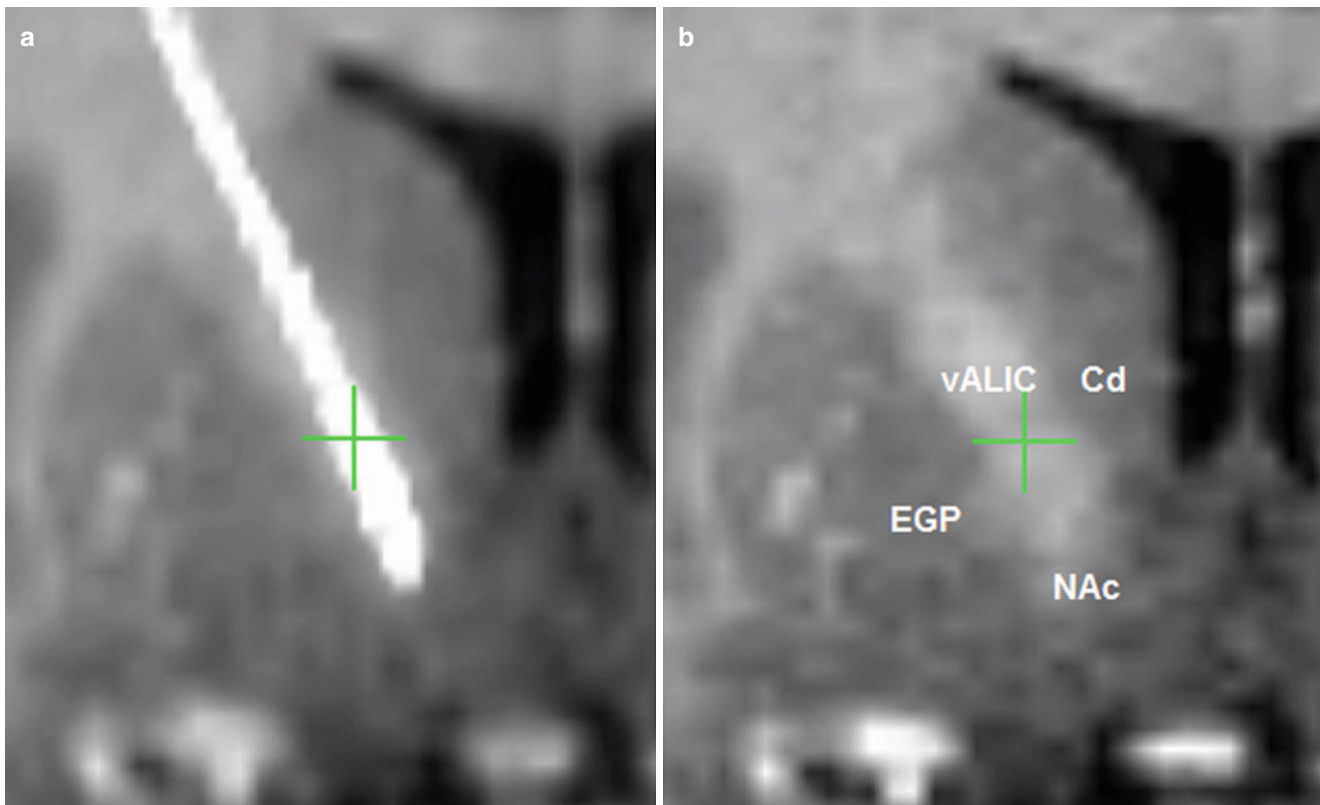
Fused coronal images of stereotactic T1-weighted MRI and co-registered follow-up CT showing representative right-sided quadripolar electrode targeting the nucleus accumbens (NAc). The artefacts of the four individual electrode contacts are visible as separately distinguishable thickenings and interspace 2/3 is marked by the *green cross*
